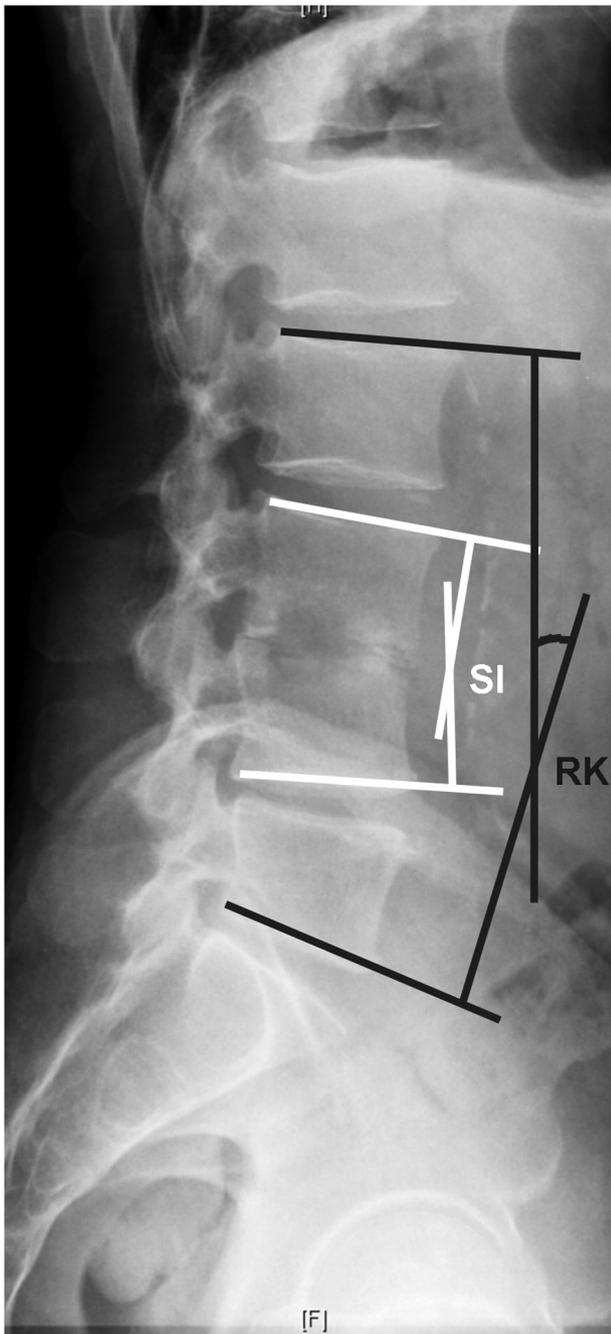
Measurement of regional kyphosis (RK) and the sagittal index (SI) on preoperative lateral radiograph.
